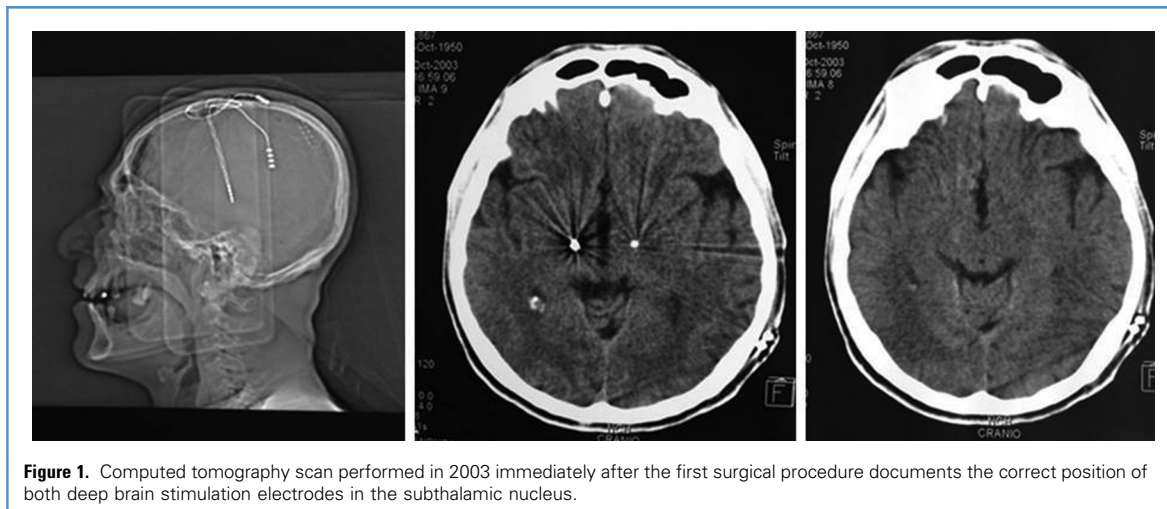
Computed tomography scan performed in 2003 immediately after the first surgical procedure documents the correct position of both deep brain stimulation electrodes in the subthalamic nucleus.
